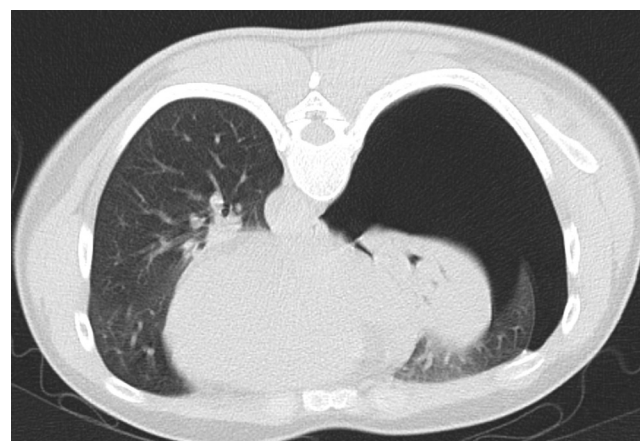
CT Thorax shows massive right pneumothorax with collapsed right lung lobes
